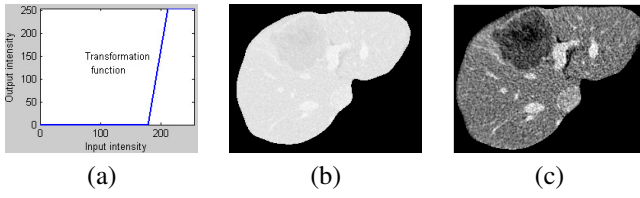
Contrast enhancement of CT volume. (a) Transformation function; (b) The original CT slice; (c) The contrast-enhanced CT slice by histogram stretching.
